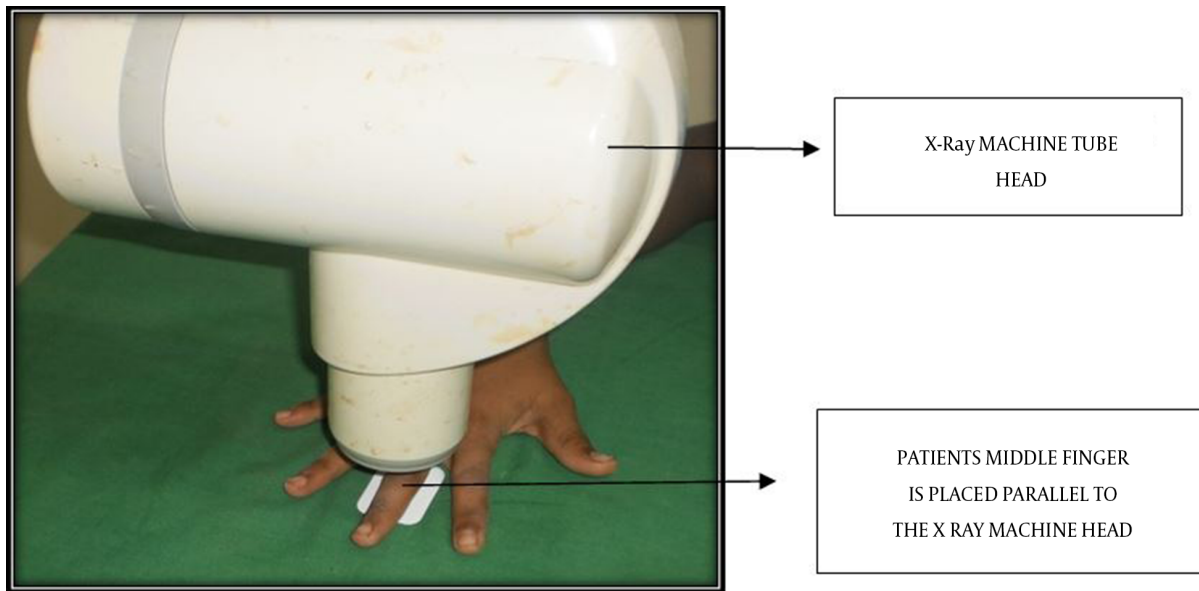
X-ray Tube and Subject positioning for MP3 radiograph
